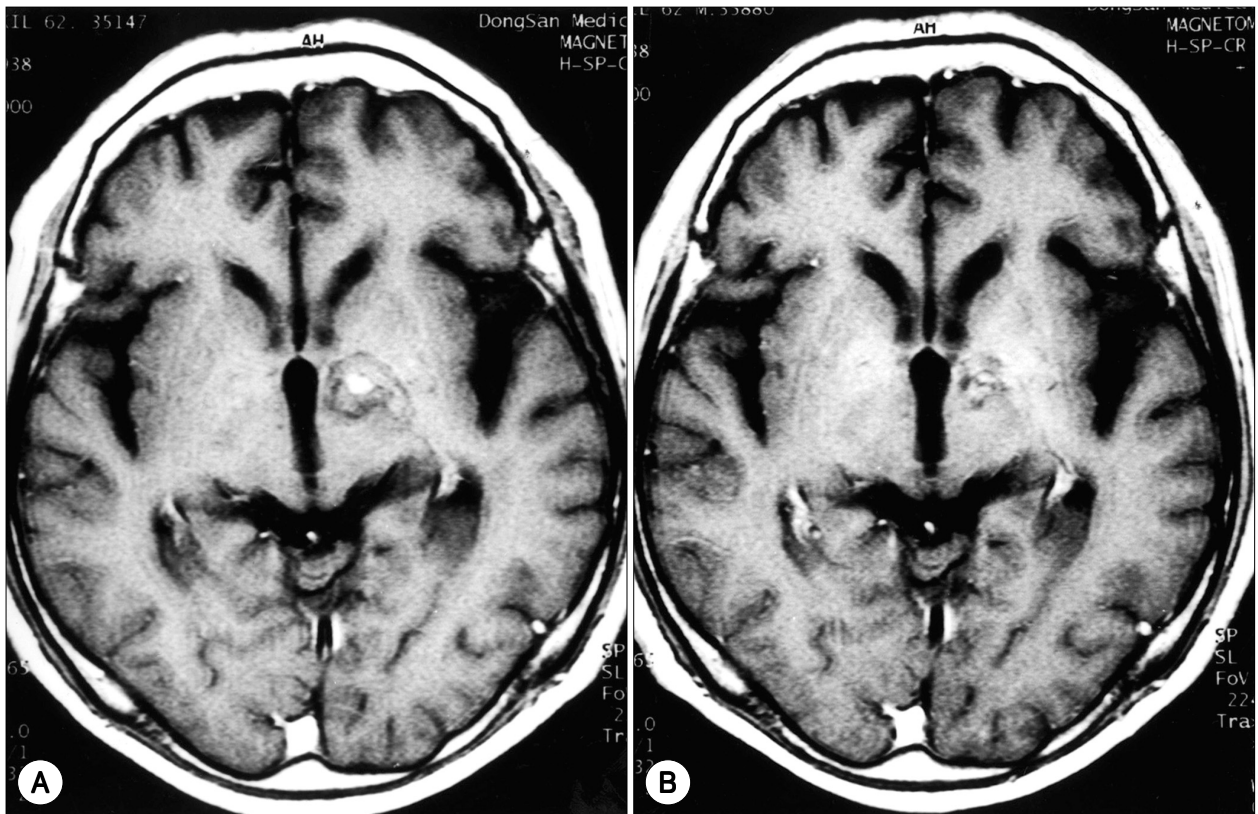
Follow-up enhancing MR image after preirradiation methotrexate-based chemotherapy showed minimal residual tumor in basal ganglia on the end of the 5th week(A), but complete radiographic response was noted on the end of the 10th week(B). The suprasellar and cerebellar lesions also disappeared.
